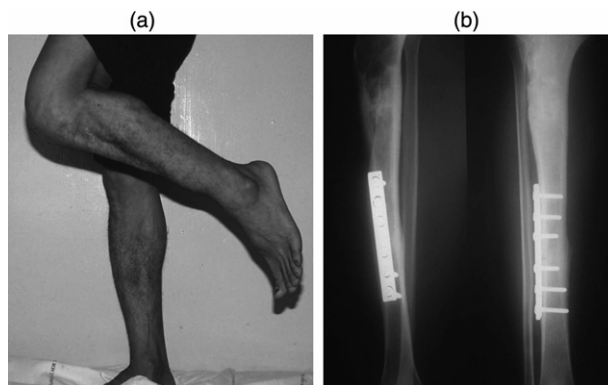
Patient no. 8. (a) Photograph showing 2-year post-operative status of a 26-year-old patient with an osteosarcoma at left proximal tibia after extracorporeal irradiation and re-implantation ECI of osteochondral graft. (b) Post-operative radiograph after wide resection and ECI of an osteochondral graft at proximal tibia in this patient. Stabilization was achieved by a 6-hole narrow plate and screws. Radiograph after 24 months shows a callus and stable implants.
